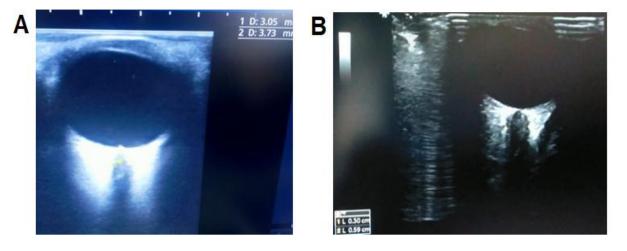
Two-dimensional ocular sonography for measurement of ONSD in control (A) and in patient with acute hepatitis and hepatic encephalopathy grade II (B).
